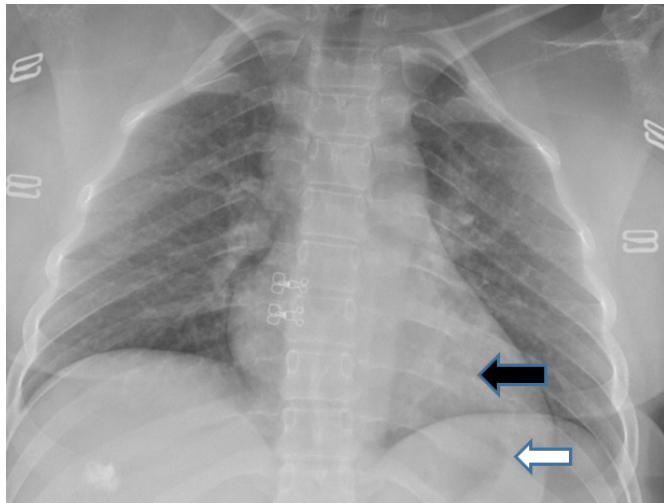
The chest X-ray shows a left-sided heart (black arrow) and gastric fundus gas (white arrow)
